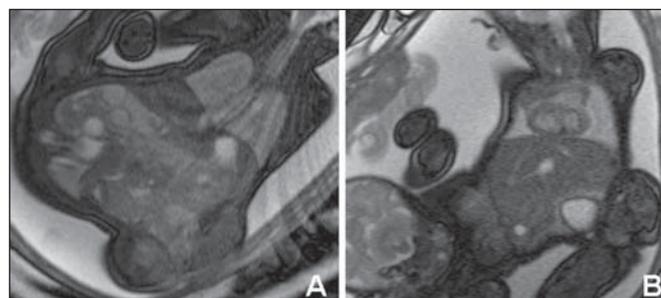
Fetal MRI T2-weighted image showing the *dicephalus tetrabrachius-dipus* conjoined twin. The fetus at right presents with a left diaphragmatic hernia. Mediastinal structures (heart and large vessels) and pulmonary hypoplasia (A) are identified. Hepatic fusion is also visualized (B).
